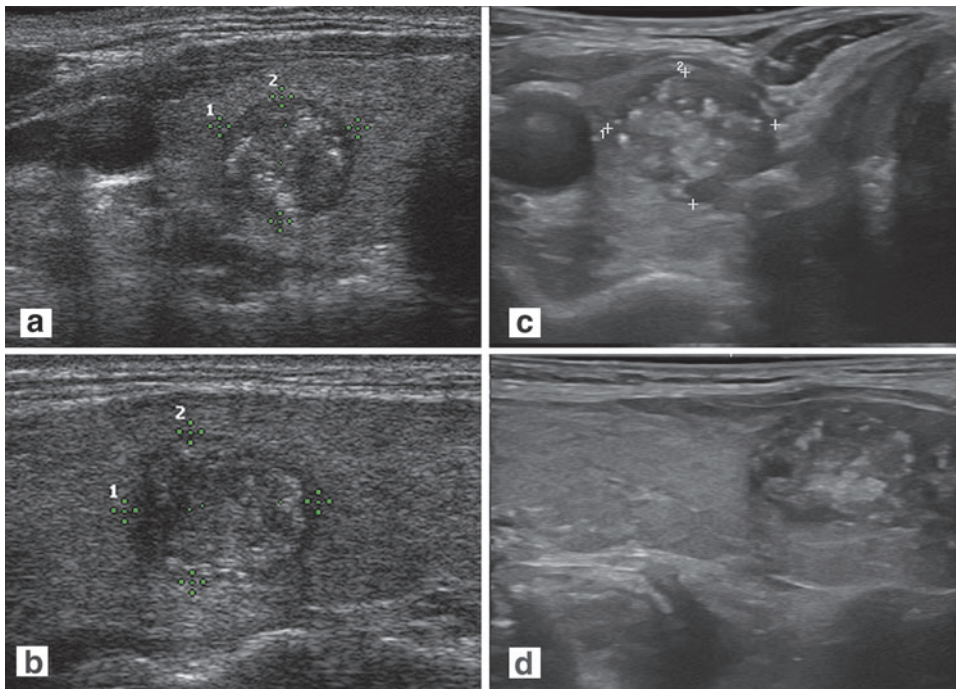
Compound spatial imaging. (a, b) Ultrasound images of a papillary carcinoma taken in 2003 on a high-resolution ultrasound machine before the utilization of spatial compound imaging. (c, d) Images from a different patient with papillary carcinoma taken in 2021 using a machine with compound imaging. The newer images have less speckle and provide a more realistic and detailed image.
